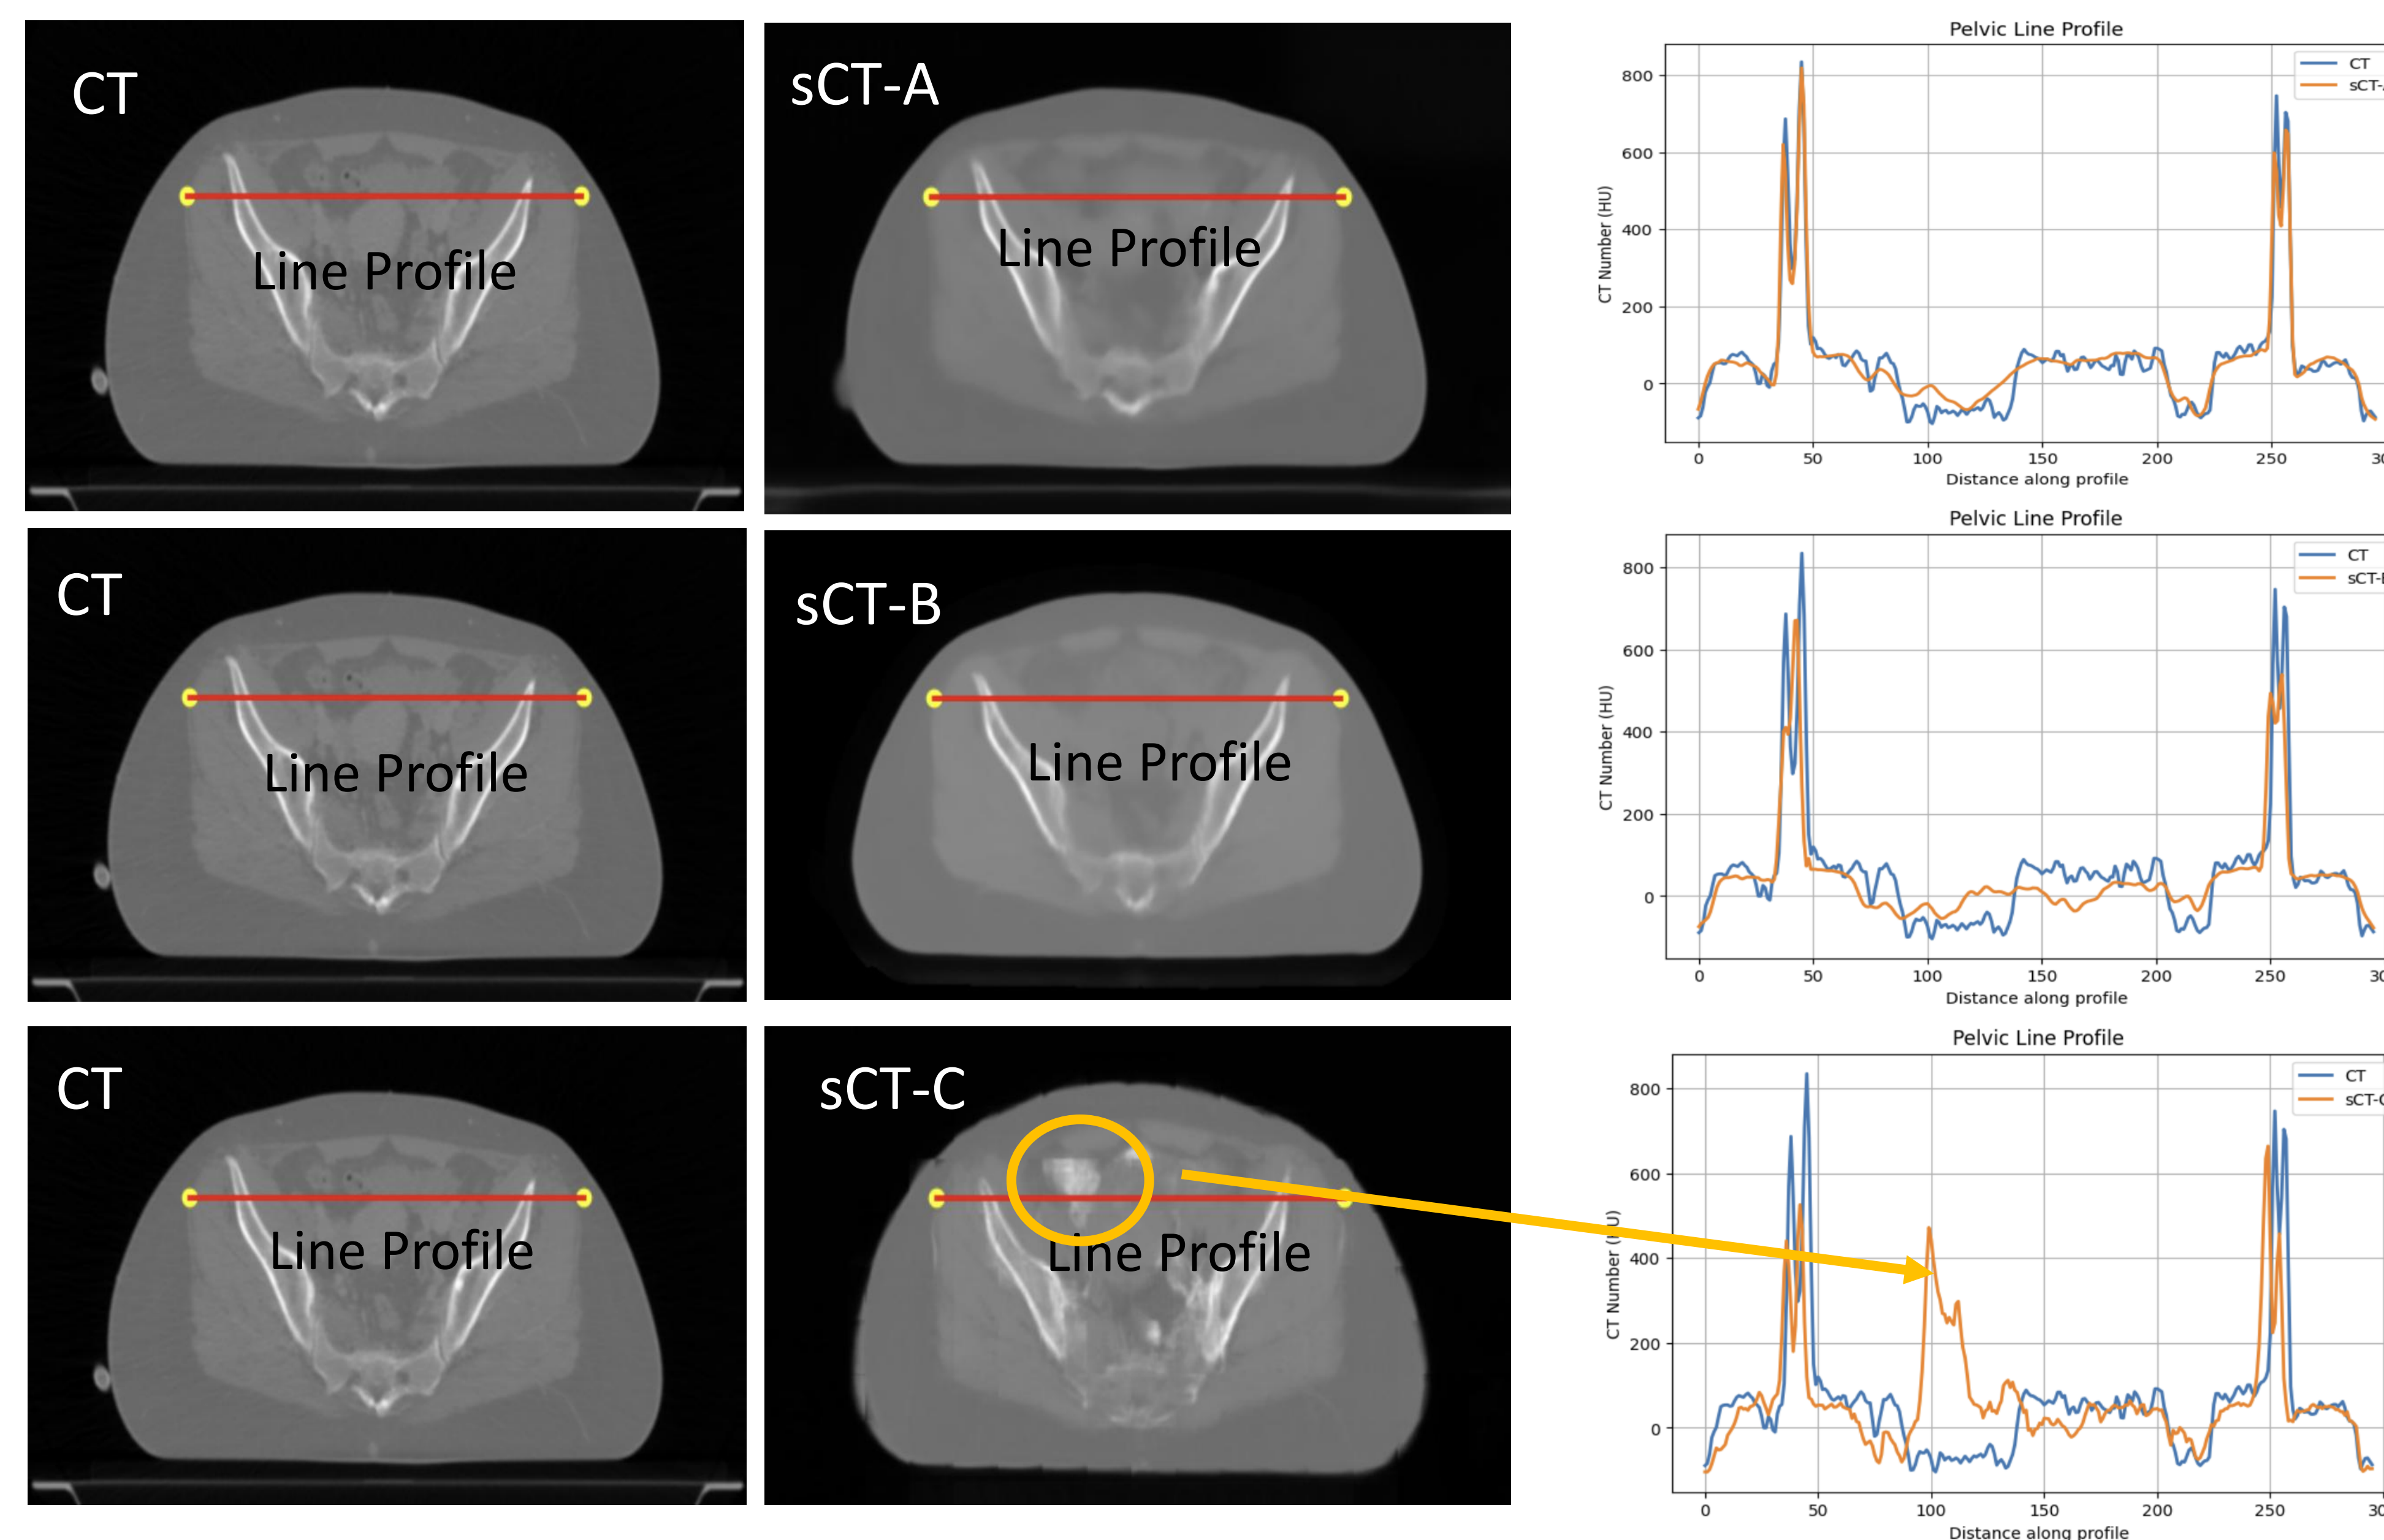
CT and sCT line profiles showing mild smoothing in A, greater detail loss in B, and soft-tissue misclassification as bone in C, highlighted by the orange circle and corresponding high-HU peak.
